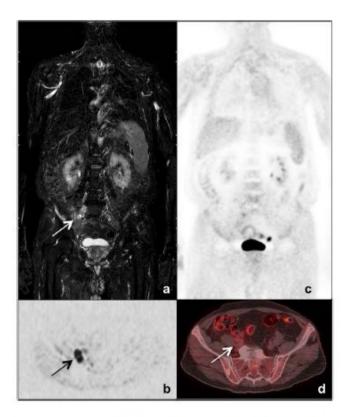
Post-therapy WB-MR/DWIBS and ¹⁸F-FDG PET/CT performed in a 78-year-old man affected by nodular sclerosis cHL, stage II. a Coronal WB-MR STIR sequence, b axial DWIBS image of the pelvis, c coronal WB PET and d axial fused PET/CT image of the pelvis. WB-MR/DWIBS shows residual nodes in the pelvic basin, in the right external iliac site, not detected byPET, even if enlarged lymph nodes are still visible on CT
